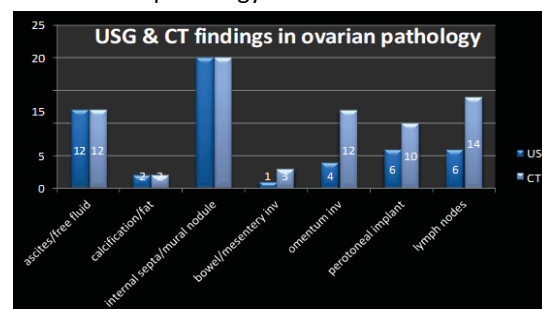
USG and CT findings in ovarian pathology
